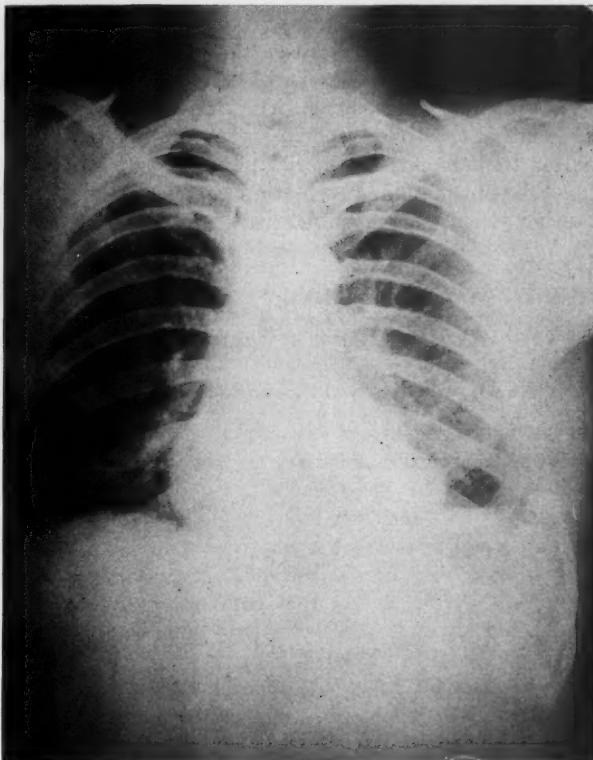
Chest roentgenogram at time of discharge
